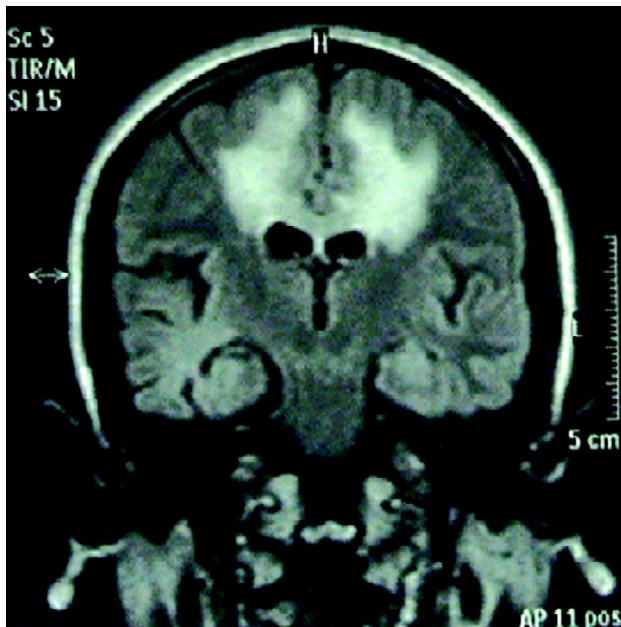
Follow-up MRI (17/04/09) – Coronal FLAIR image showing bifrontal white matter hyper-intensities extending across the corpus callosum.
